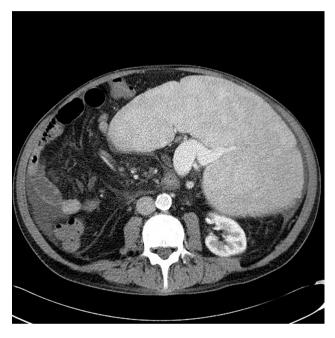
Axial CT sections demonstrating massive splenomegaly with a severely dilated splenic vein.
